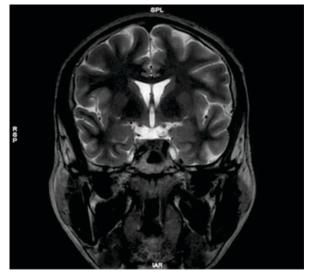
Magnetic resonance imaging of brain having normal finding
